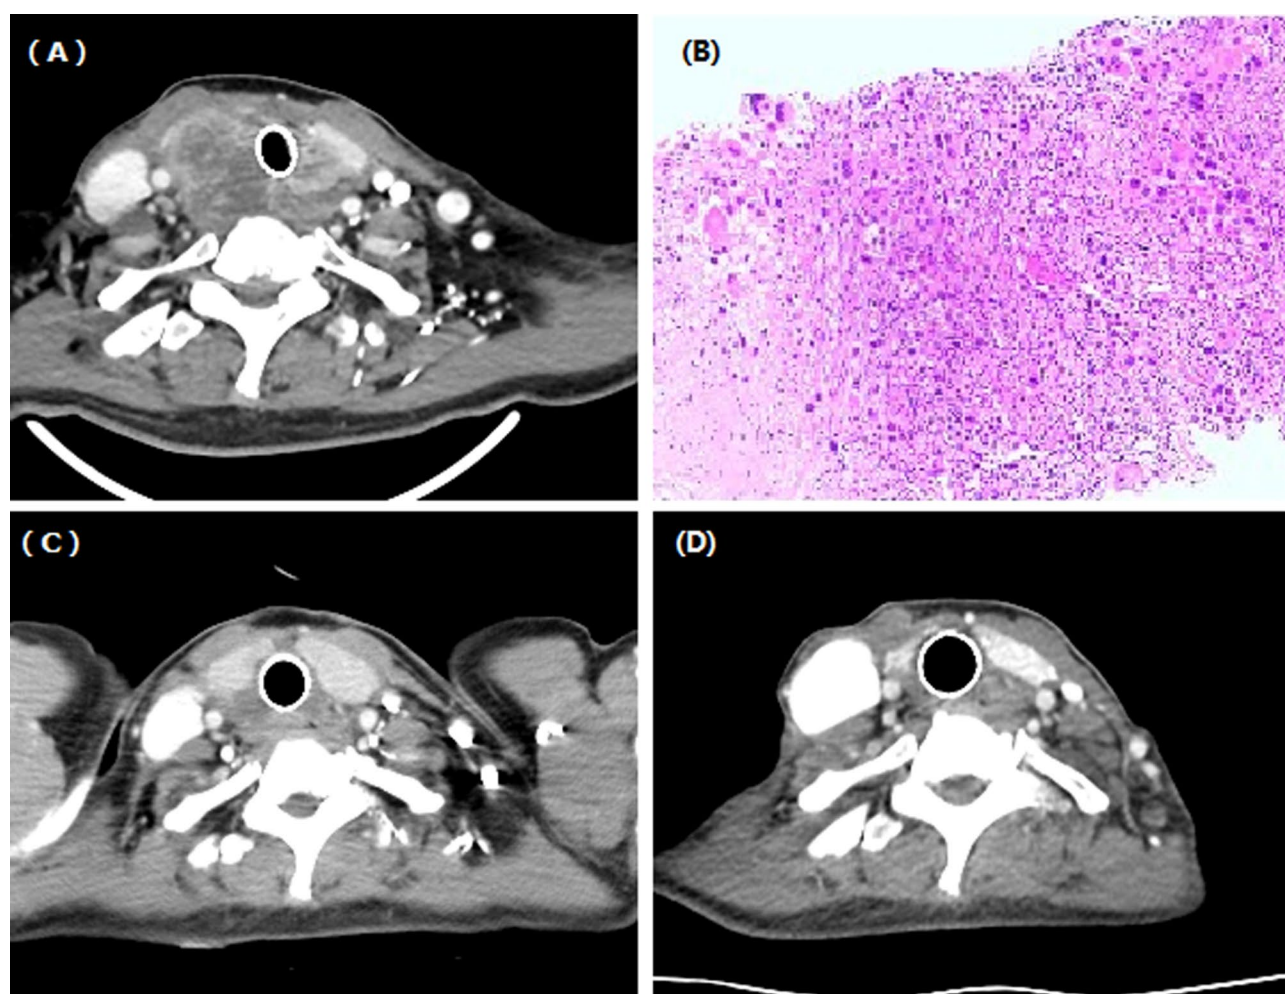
Images of a 50-year-old female with esophageal cancer in upper esophagus and cervical metastasis. (A) Esophageal cancer invaded the trachea and caused airway stenosis, and an airway stent was inserted. (B) The pathology of the right neck tumor indicated a squamous cell carcinoma. (C) After 2.4 months, chest CT scan revealed a shrunk mass in the upper esophagus. (D) The tumor disappeared 13.3 months after first session of DEB-TACE
